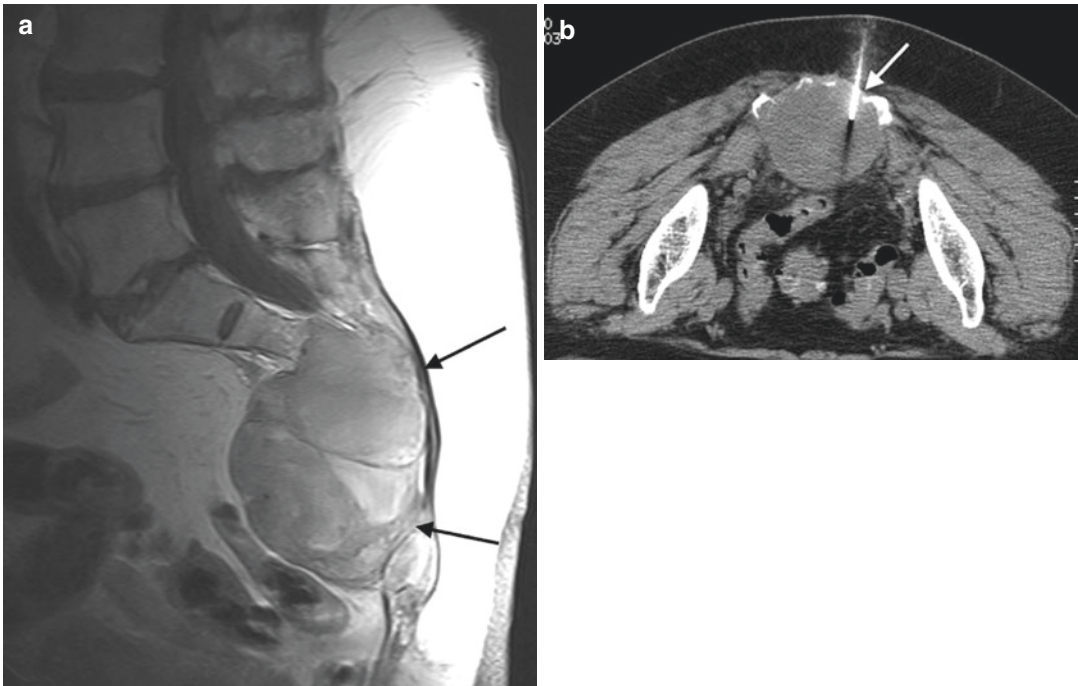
Chordoma. Contrast-enhanced T1-weighted sagittal image (a) shows large moderately enhancing septated mass within the distal sacrum (arrows); the mass
